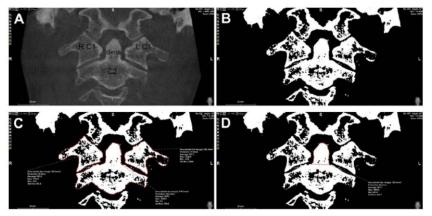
A, The selected coronal slice after angulation adjustment of the cone beam computed tomography (CBCT) image. The right (R C1) and left (L C1) parts of the first and the second vertebrae (C2) with its odontoid process (dens) appear in this slide. B, Adjusting the window width and level to 0 and 400 gray values, respectively. C, Calculating the radiographic density (RD) of the left and right parts of the first and the second vertebrae. D, the dens.
